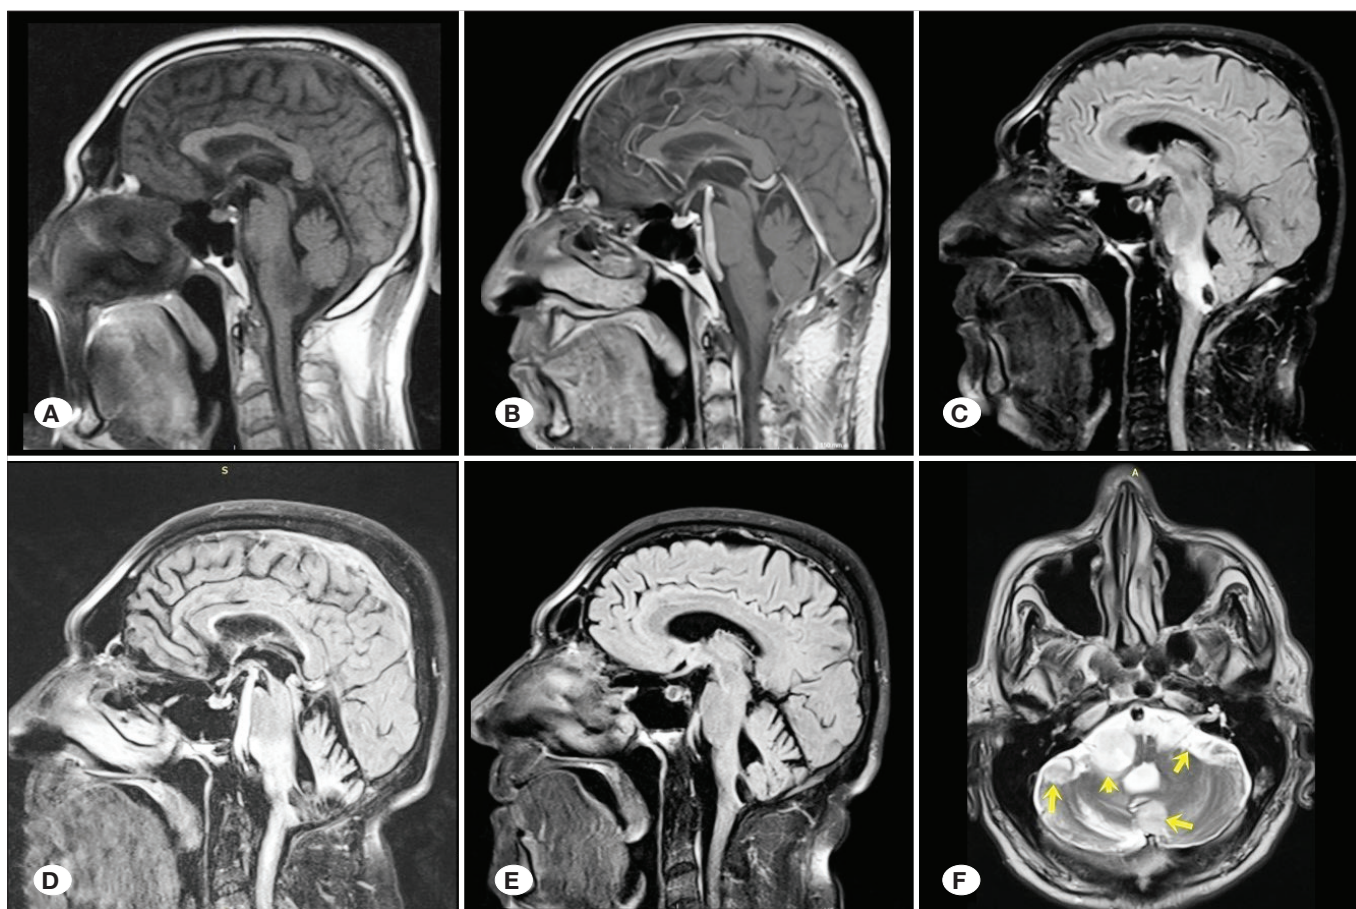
Patient #17. Medullary GBM. A) Preoperative sagittal T1W MRI at the time of diagnosis. B) T1W contrast enhanced sagittal MRI after first operation. C) FLAIR sagittal MRI after radiotherapy (2015). D) Sagittal T1W contrast enhanced MRI shows residual tumor (2018). E) FLAIR sagittal MRI after second operation. F) T2W axial MRI shows multiple metastatic lesions (2020).
